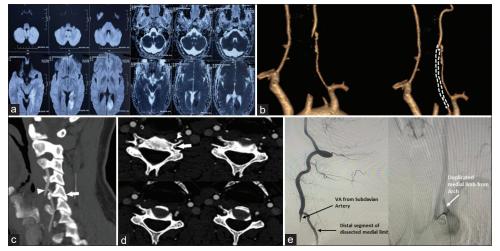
(a) MRI brain showing restricted diffusion in left PCA territory involving left medial temporal lobe and occipital lobe. (b) 3D reconstructed image of CT angiogram of neck showing the dissected medial limb and its probable course (dotted lines). (c) CT angiogram serial axial view shows medial limb (arrowhead) and lateral limb inside the transverse foramen (arrow) uniting at C5-6 level. (d) CT angiogram sagittal view showing the two limbs of duplicated VA uniting (arrowhead) after the lateral limb enters at C6 transverse foramen (arrow). (e) DSA confirming the CTA findings of distal tapering end and proximal origin from arch of medial limb of duplicated vertebral artery and lateral limb arising from subclavian artery
